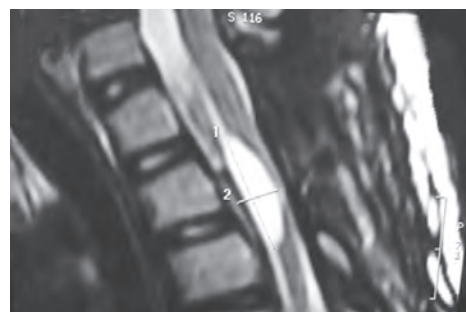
MRI of the upper dorsal spine showing a ventral intradural cystic tumour
